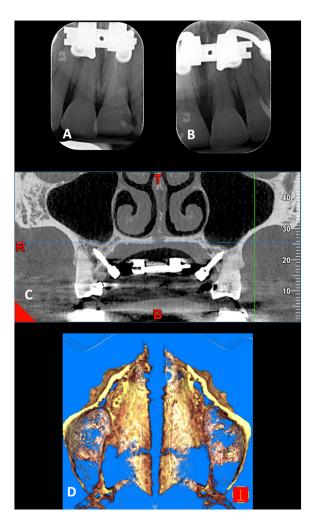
A, Periapical radiograph 2 weeks after activation; B, After midpalatal suture opening; C and D, CBCT imaging at the end of the expansion period.
